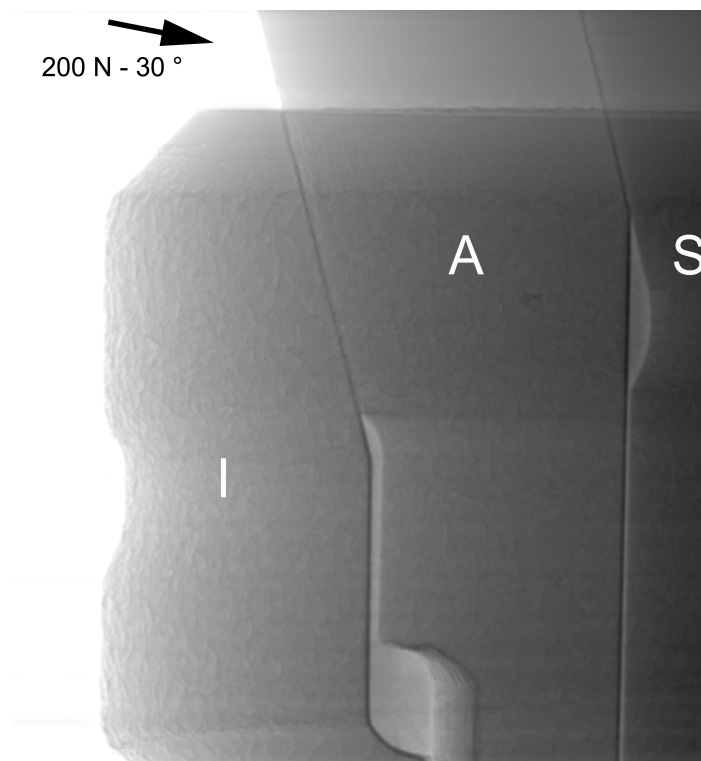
Radiographic images of virgin Ankylos c/x IAC (AN01) – 4a, and fatigue loaded Straumann BoneLevel (ST02) – 4b under static load of 200 N in a 30 ° angle. I – implant, A – abutment, S – screw.
